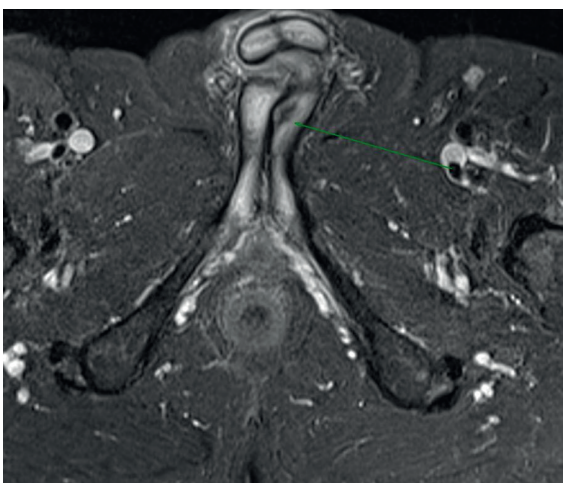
Magnetic resonance imaging demonstrating a low T2 signal within the left corpus cavernosum at the bulbocavernosum junction suggestive for fibrosis.
